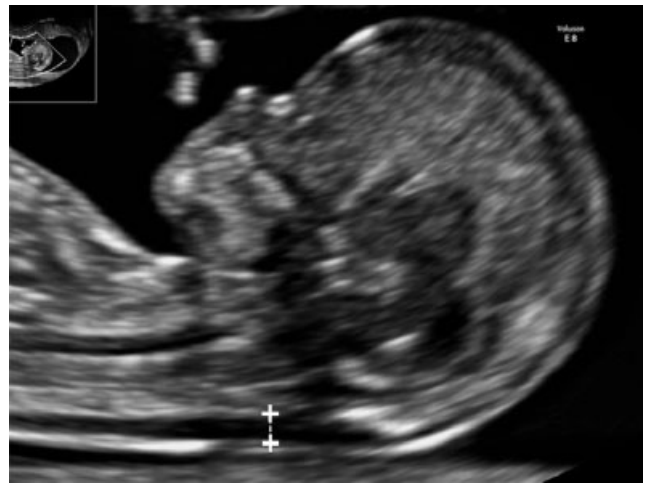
Sonographic measurement of nuchal translucency thickness.
